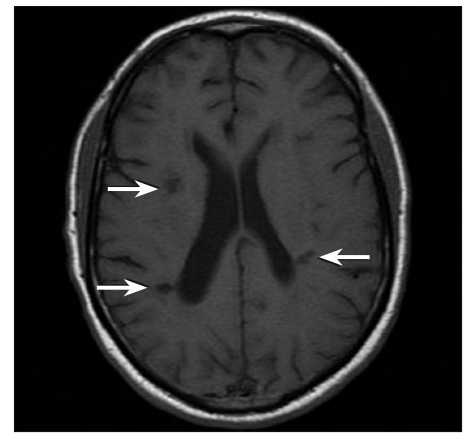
Axial T1-weighted MR image shows hypointense white matter foci (arrows) that did not demonstrate restricted diffusion on diffusion-weighted imaging (not shown) and are compatible with remote infarcts.
